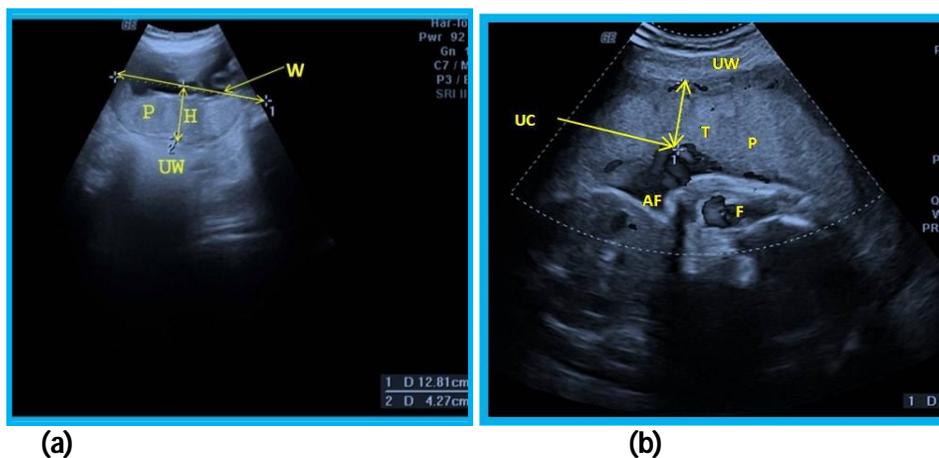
Ultrasonogram showing landmarks for measuring (a) height and width of placenta. (b) – thickness of placenta. (P= Placenta, H= Height of placenta, W= Width of placenta, UW= Uterine wall, T= thickness of placenta, UC= Umbilical cord, AF= Amniotic fluid, F= Foetus).
